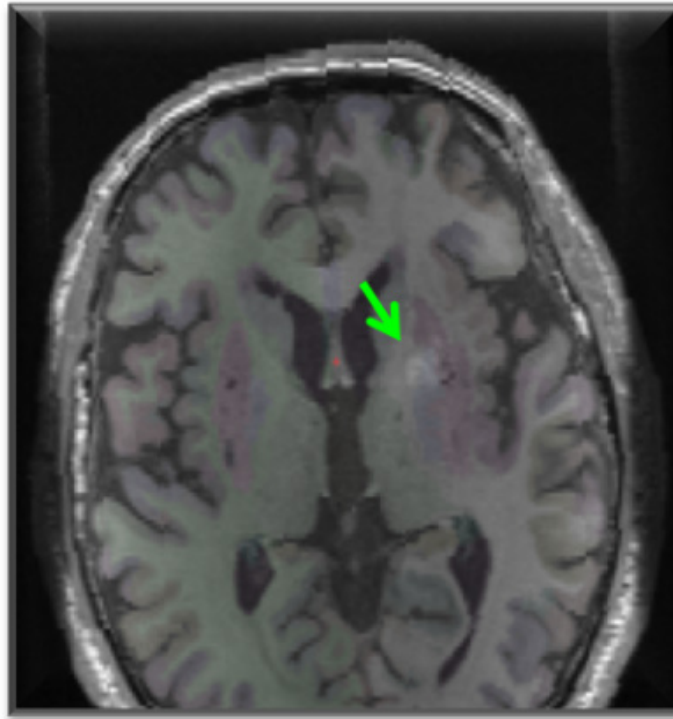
T1 Axial MRI with subcortical labeling. Note the hyperintense signal of the left caudate head and the left pallidum area.
